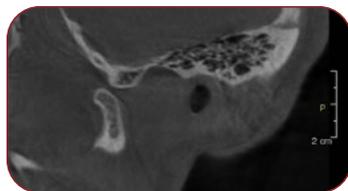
b. CBCT oblique sagittal section of the left TMJ with open mouth (P-posterior). The condyle slides in front of the articular tubercle of the temporal bone (subluxation).
